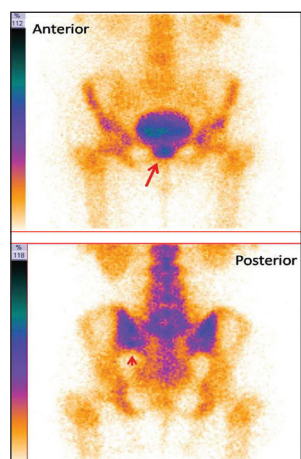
Technetium-99m methylene diphosphonate bone scintigraphy, arrow in pelvis anterior and posterior planar images shows intense tracer uptake in symphysis pubis and mild increased uptake in left sacroiliac joint
